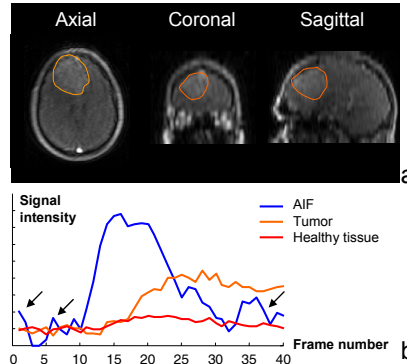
Whole-brain DCE-MRI in a patient with a large brain tumor (a) using the proposed data acceleration scheme. The signal intensity curve of the tumor shows strong contrast enhancement compared to healthy tissue (b), which is due to contrast leakage across the blood brain barrier. Notice that the inflow effects due to the lack of an SR pulse corrupt only the AIF (arrows) and not the tissue curves.
